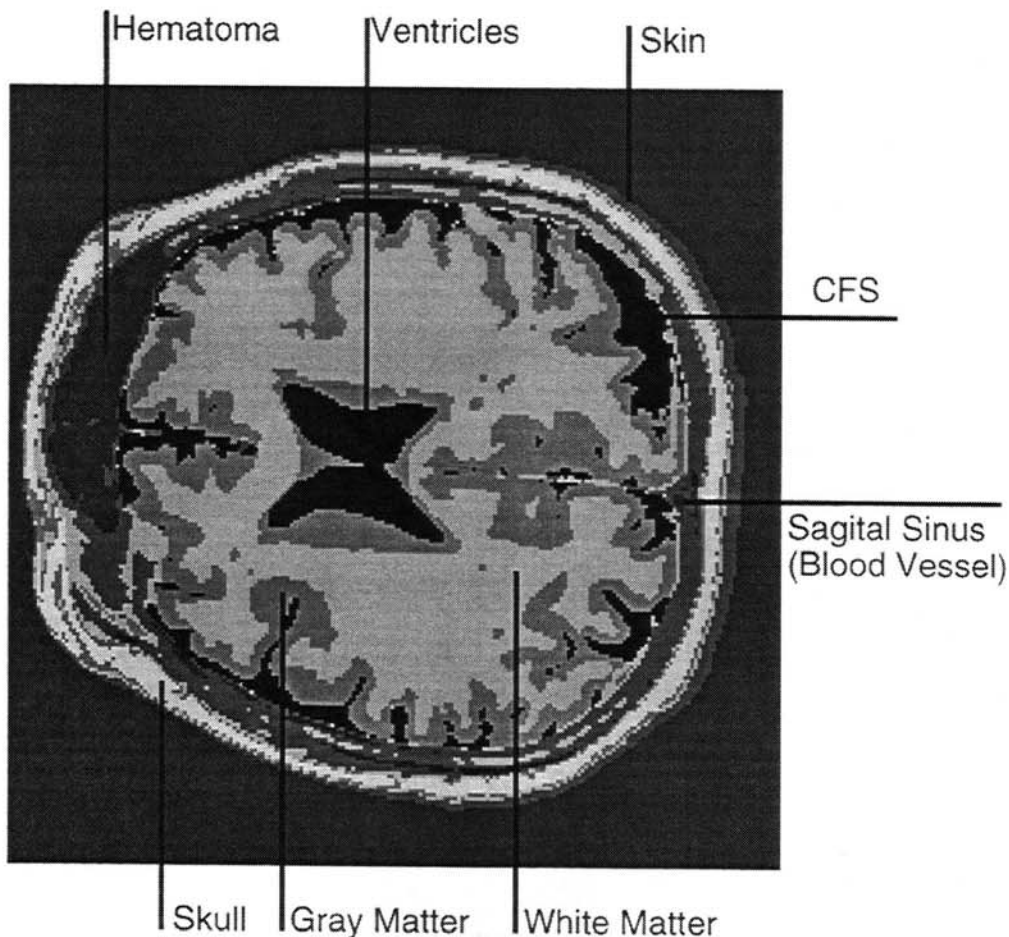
Segmented 2D-MRI slice through human head just above the eyebrow.
